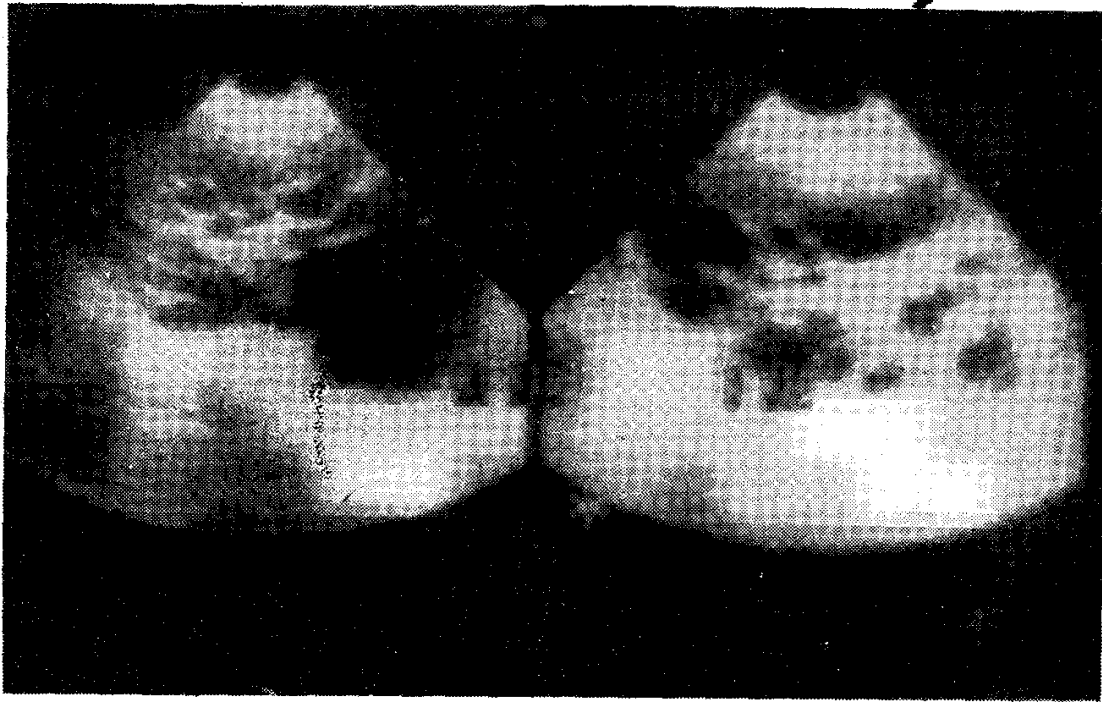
Ultrasonogram demonstrating bilateral multiple renal cysts.
